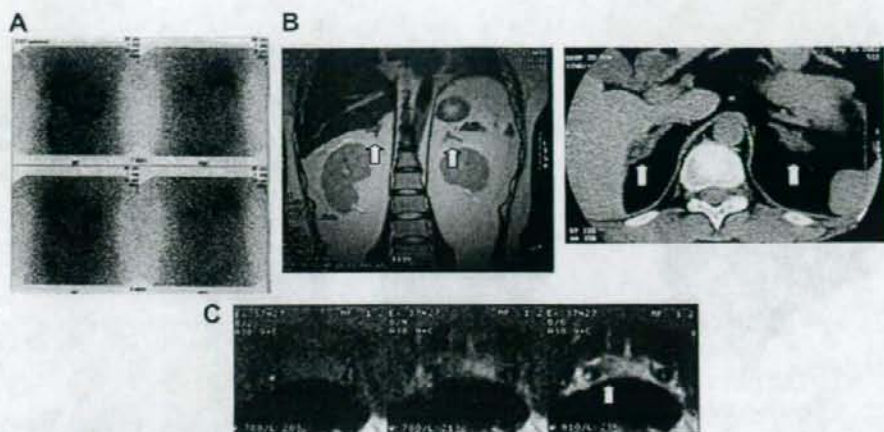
Imaging findings in the proband. (A) Adosterol Scintigraphy: Evident uptake was found in bilateral adrenal glands. (B) Abdominal MRI and CT scan: No evident abnormality was found in bilateral adrenal glands. (C) Pituitary MRI: Low intensity nodule of 9 × 7 mm size was found in right side of pituitary.
